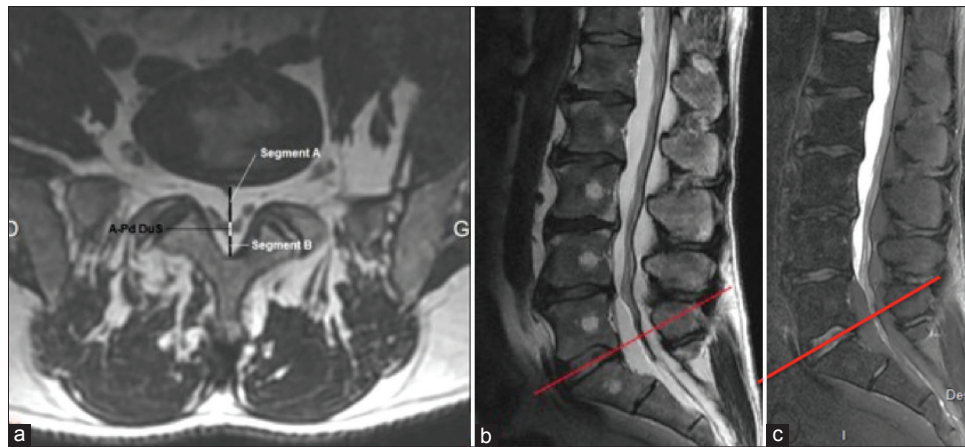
(a) Axial T2-weighted magnetic resonance imaging. A-Pd DuS anteroposterior width of the dural sac; Segment A: anteroposterior width of the epidural fat at the ventral epidural space; Segment B: anteroposterior width of the epidural fat at the dorsal epidural space. (b) sagittal T2-weighted magnetic resonance imaging. The red line shows the selected level. (c) Stir sequence magnetic resonance imaging
